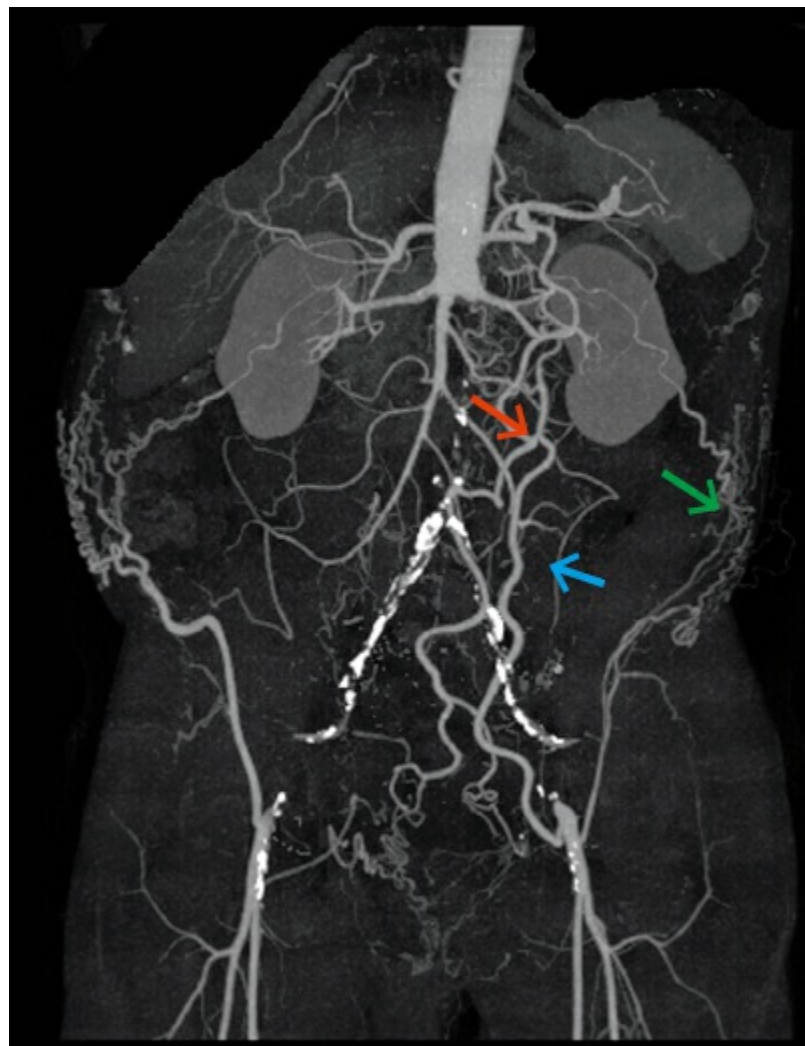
CTA with 3D reconstruction demonstrating severe aortoiliac occlusive disease with juxtarenal aortic occlusion. Note the extensive collateral networks reconstituting the inferior mesenteric artery (*red arrow*: marginal artery) and femoral arterial segments (*blue arrow*: inferior epigastric artery) (*green arrow*: subcostal arteries and superficial iliac circumflex artery collaterals).
